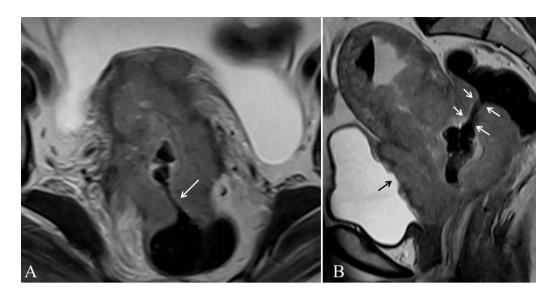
(A) Axial and (B) Sagittal T2 weighted MRI showing tumor extension to rectum causing rectocervical fistula (white arrow) and also to posterior wall of urinary bladder (black arrow), staged IVA.
